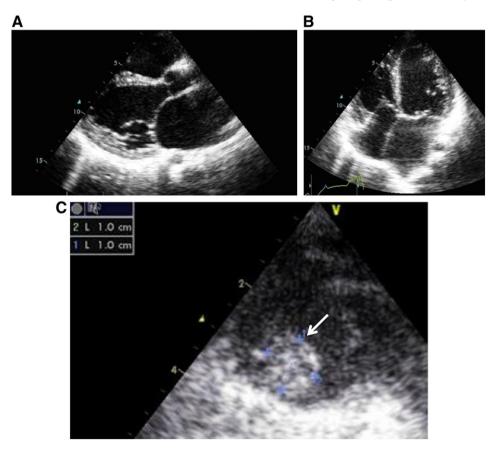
Echocardiographic findings in pediatric DCM. (A) Parasternal long axis view in a 13 year-old patient with DCM and severe biventricular dysfunction showing enlargement of the cardiac chambers. (B) Four chamber echocardiogram shows biventricular dilation, biatrial enlargement and a marked trabecular meshwork in the lateral wall. (C) Echocardiography showing a large mobile thrombus (arrow).
